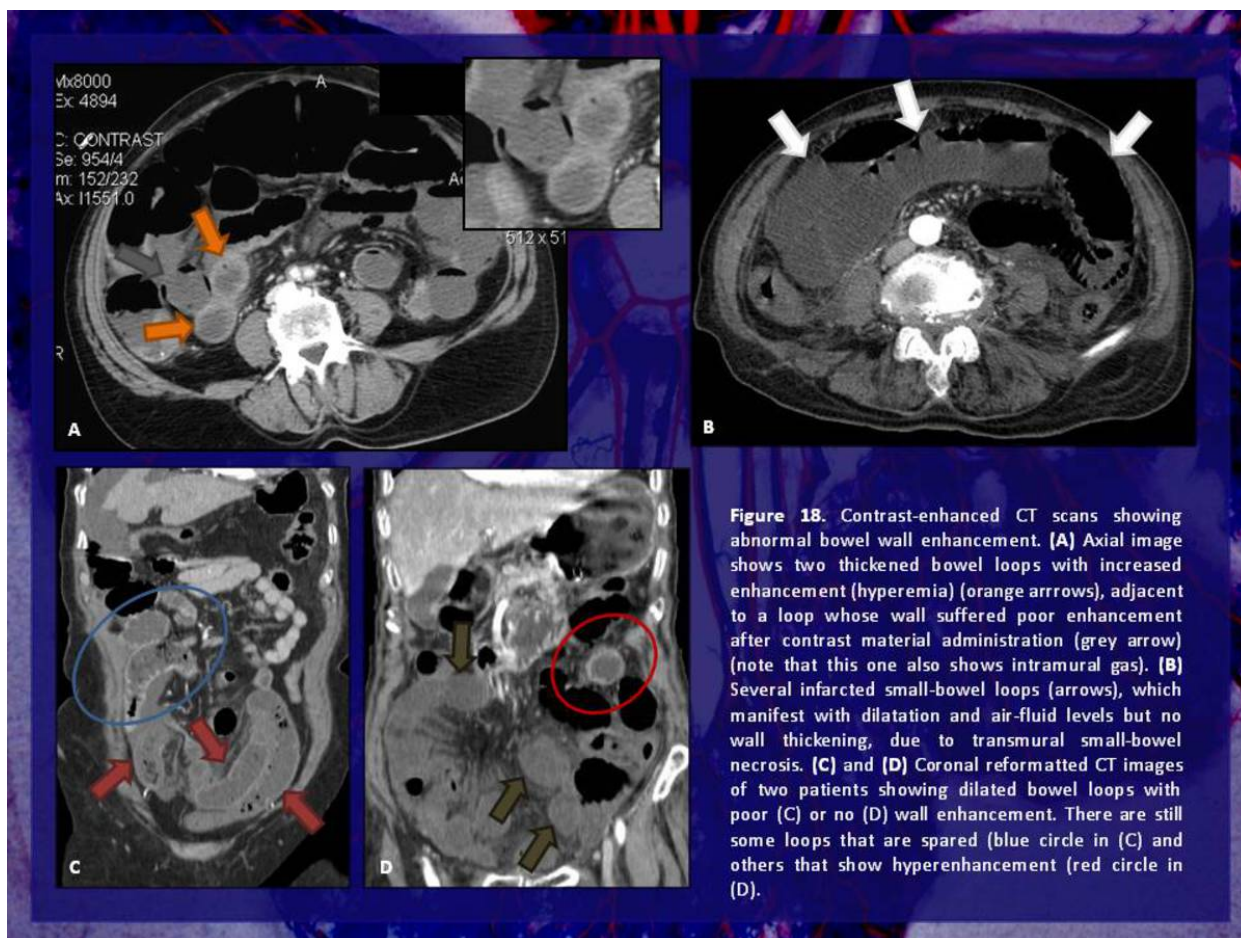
Contrast-enhanced CT scans showing abnormal bowel wall enhancement. (A) Axial image shows two thickened bowel loops with increased enhancement (hyperemia) (orange arrows), adjacent to a loop whose wall suffered poor enhancement after contrast material administration (grey arrow) (note that this one also shows intramural gas). (B) Several infarcted small-bowel loops (arrows), which manifest with dilatation and air-fluid levels but no wall thickening, due to transmural small-bowel necrosis. (C) and (D) Coronal reformatted CT images of two patients showing dilated bowel loops with poor (C) or no (D) wall enhancement. There are still some loops that are spared (blue circle in (C)) and others that show hyperenhancement (red circle in (D)).
